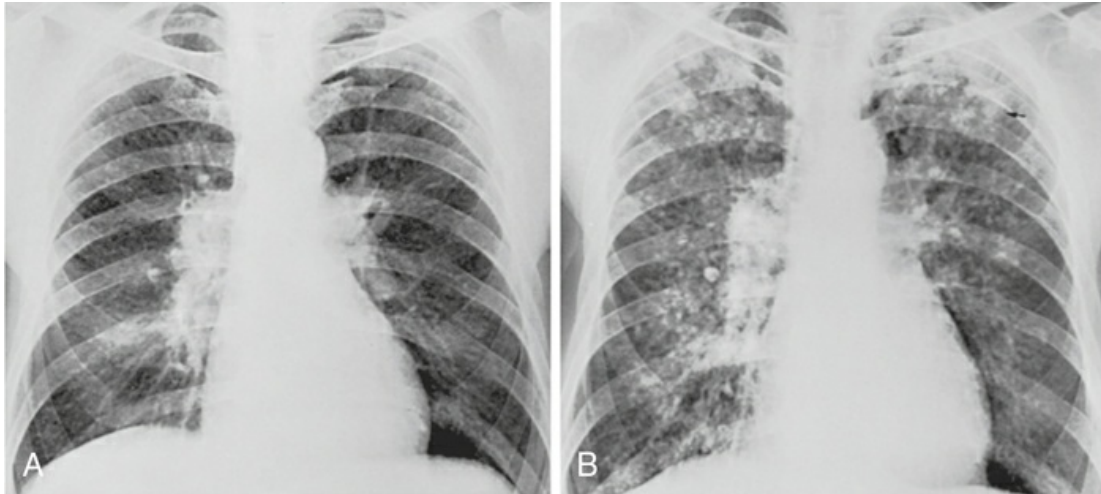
Radiographic appearance of (A) simple and (B) complicated silicosis in same patient. A, Small nodules are present throughout both lungs, particularly in upper zones. A reticular component is also seen. B, Nodules have become larger and are coalescent in upper zones. One of the confluent shadows on left shows cavitation (*arrow*). Interval between radiographs shown in A and B is 11 years. *Source:* (From Fraser, R. G., Müller, N. L., Colman, N., Paré, P. D. [1999]. *Diagnosis of diseases of the chest* [Vol. 4, 4th ed.]. Philadelphia, PA: WB Saunders.)
